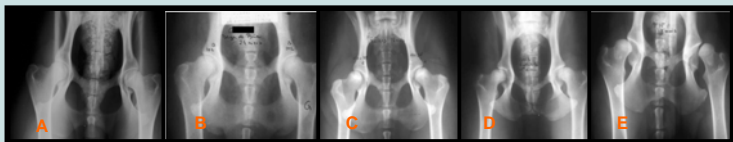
X-rays showing the different stages of the FCI score
